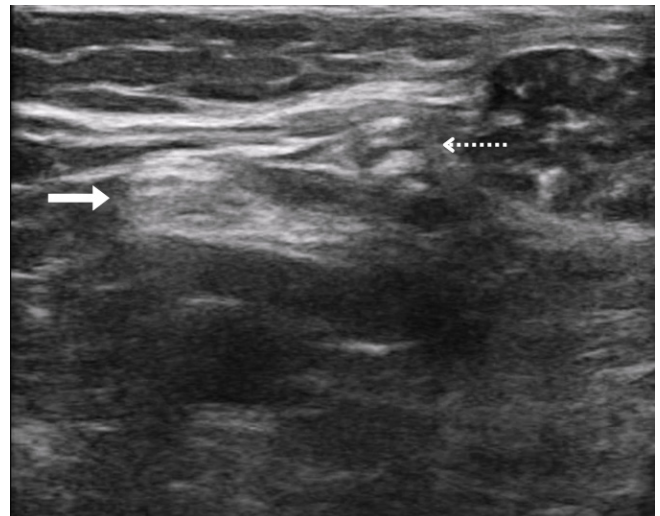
Short-axis ultrasound image at the level of the sciatic nerve bifurcation, demonstrating division into the tibial nerve and the common peroneal nerve. The solid white arrow indicates the tibial nerve, and the dashed white arrow indicates the common peroneal nerve
